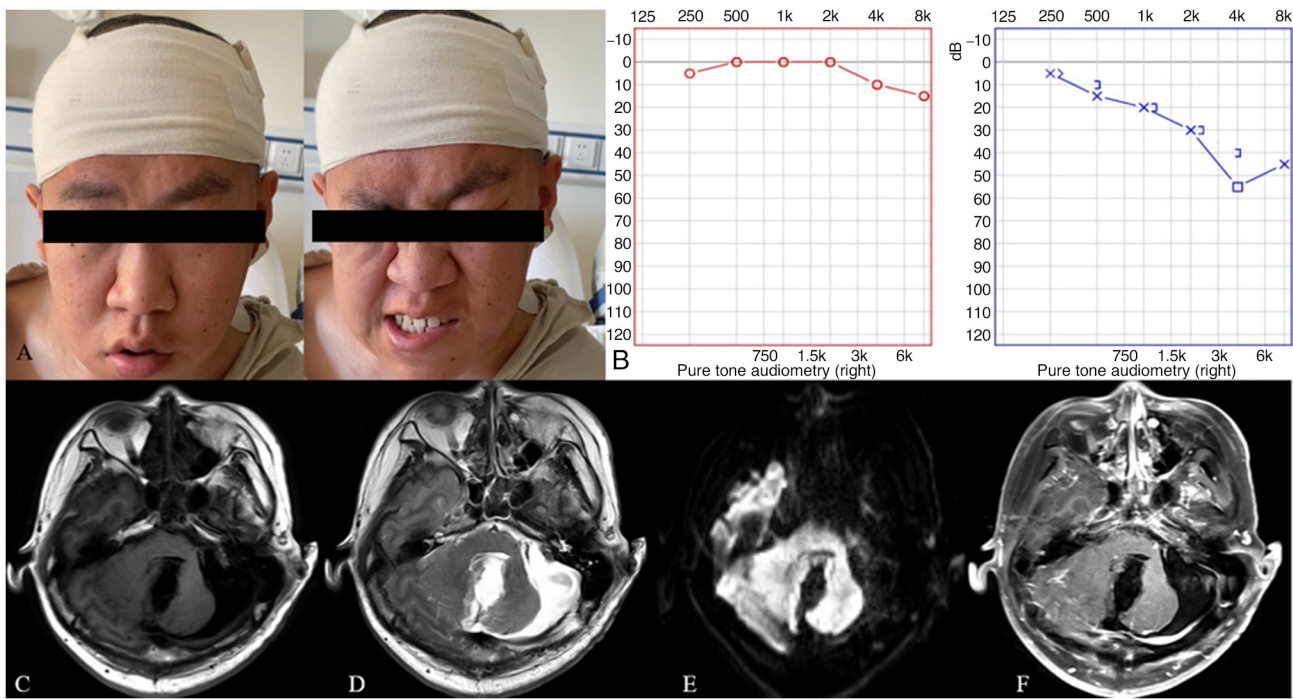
Postoperative condition. (A) Postoperative facial nerve function. The face is normally symmetrical at rest, the eyelids can be fully closed during moving (masked for anonymity) and the commissure is slightly asymmetrical (H-B II). (B) Postoperative hearing examination. Right ear: PTA=30 dB; left ear: PTA=52 dB. High-frequency hearing of air conduction in the left ear decreased after surgery, but there was still practical hearing. Postoperative magnetic resonance imaging, including (C) T1WI, (D) T2WI, (E) diffusion-WI and (F) contrast-enhanced T1WI indicated complete resection of the tumor, with no residual tumor. PTA, pure tone audiometry; WI, weighted imaging.
